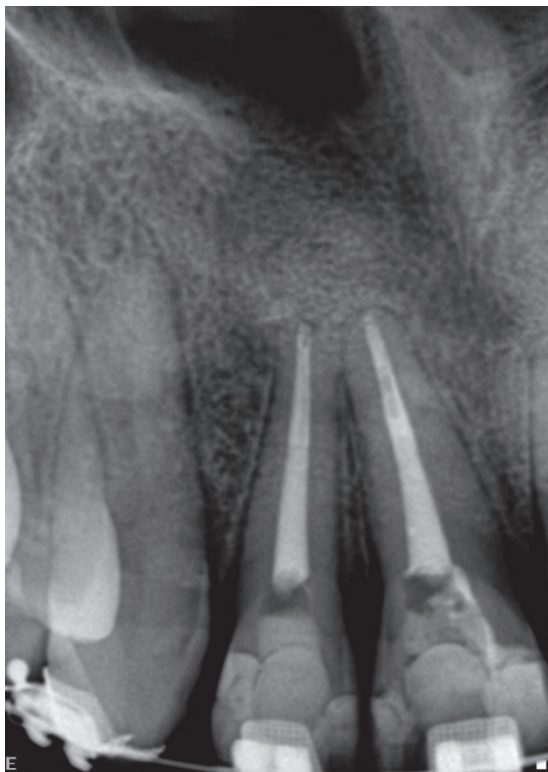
Final periapical radiograph after root canal filling
